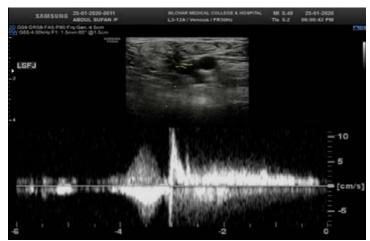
Saphenofemoral junction incompetence with reflux on Valsalva maneuver on spectral Doppler study.
